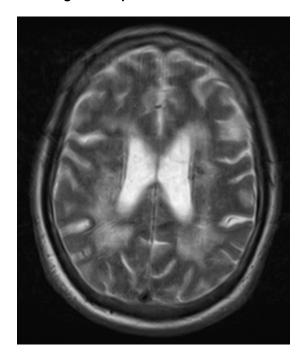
Magnetic resonance imaging (T2-weighted, axial cut, at level of basal ganglia and thalamus) showing lacune at left basal ganglia
